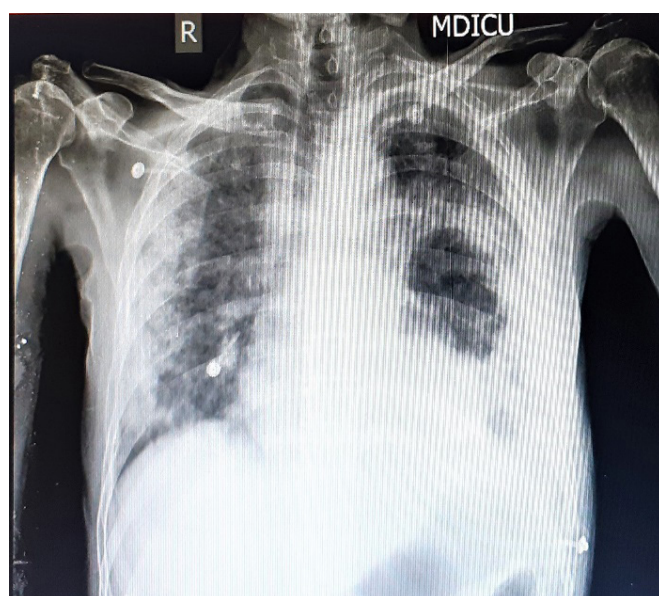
Repeat Chest Xray showing cavitation in left lobe with Bilateral Consolidation
